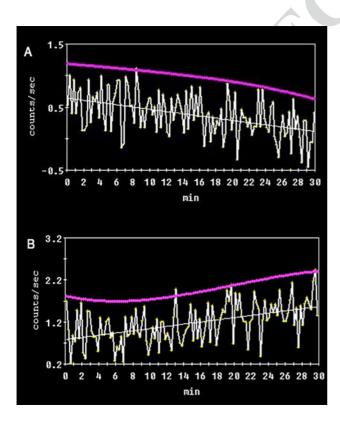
Time-activity scintigraphy curves demonstrating:  $\mathbf{a}$  falling curve, and  $\mathbf{b}$  rising curve
